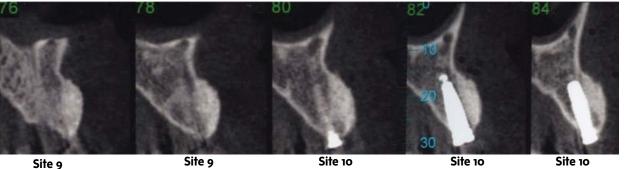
At six months, CT scans show a significant gain in bone volume horizontally. Note site 9 is suitable for narrow implant placement.
